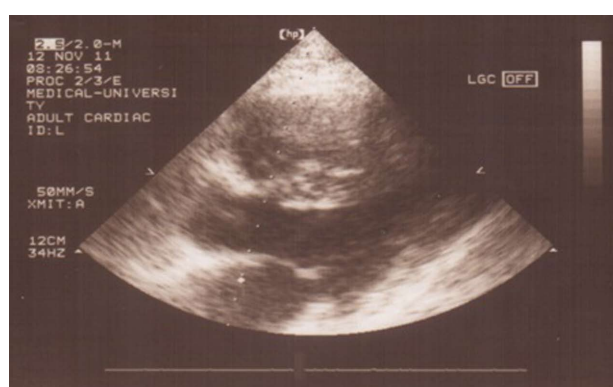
Echocardiogram of a 35-year-old patient with hypertrophic cardiomyopathy: massive hypertrophy of the interventricular septum with wall thickness 37 mm compared to posterior wall; hyperechogenic septal myocardium.
